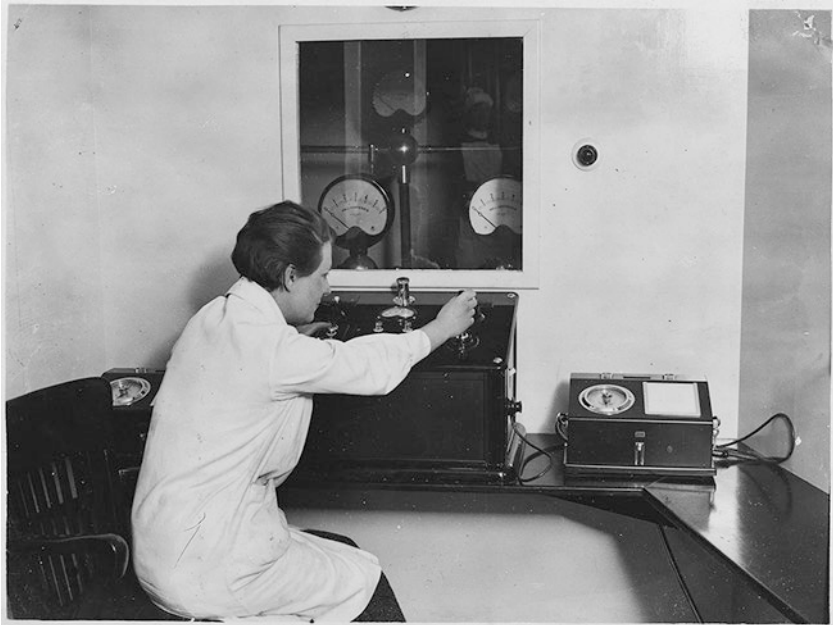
Control panel for X-rays, Marie Curie Hospital, 1934 (Photographers: Newton & Wright. Courtesy of the Medical Women's Federation)
